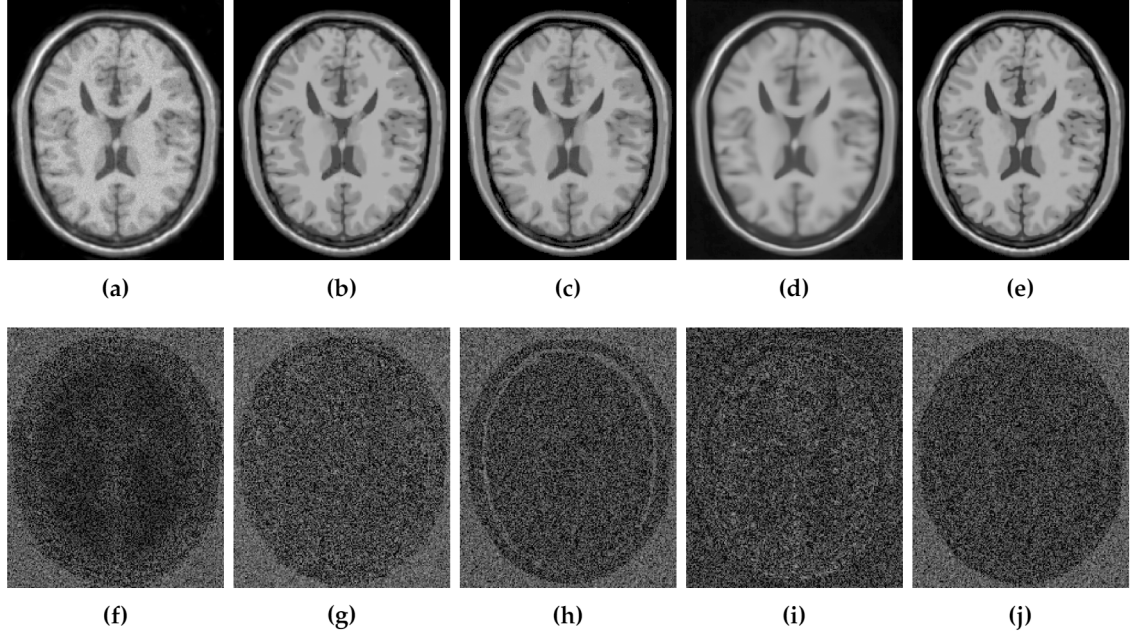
Residuals of the different results produced by the application of the methods evaluated on the noise-free T1w synthetic MR image of Figure 3.6a corrupted with 5% Rician noise. (a–e) are the denoising results of the methods KSVD, PRINLM, BM4D, DnCNN, and NLSD, respectively. (f–j) are the corresponding residuals.
